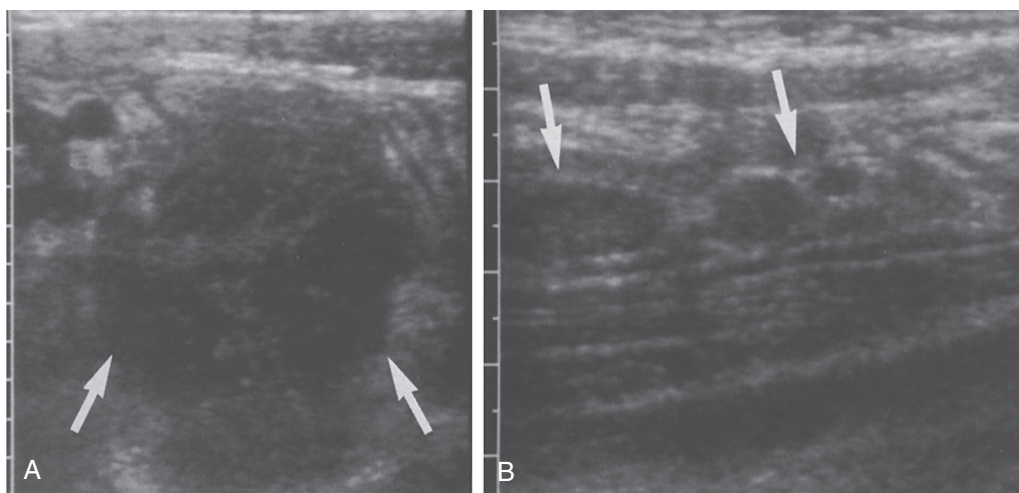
An 11-year-old girl presented with fever, diarrhea, and vomiting. Ten days before admission to the hospital, she was seen by a physician because of abdominal pain. She had been partially treated with antibiotics for a presumed “strep throat” in the interim. When she presented to the hospital, she again had pain in the right lower quadrant, especially when the ultrasound transducer was pressed over the area. A, The right-lower quadrant abscess (arrows) was quickly identified. The appendix could not be visualized. B, In scans along the psoas, multiple lymph nodes (arrows) were apparent. The child’s appendix had ruptured 1 week before admission, but her symptoms had been masked by the antibiotics that she had been given. (From Teele R, Share J. Appendicitis and other causes of intraabdominal inflammation. In: *Ultrasonography of Infants and Children*. Philadelphia: WB Saunders; 1991:348.)
